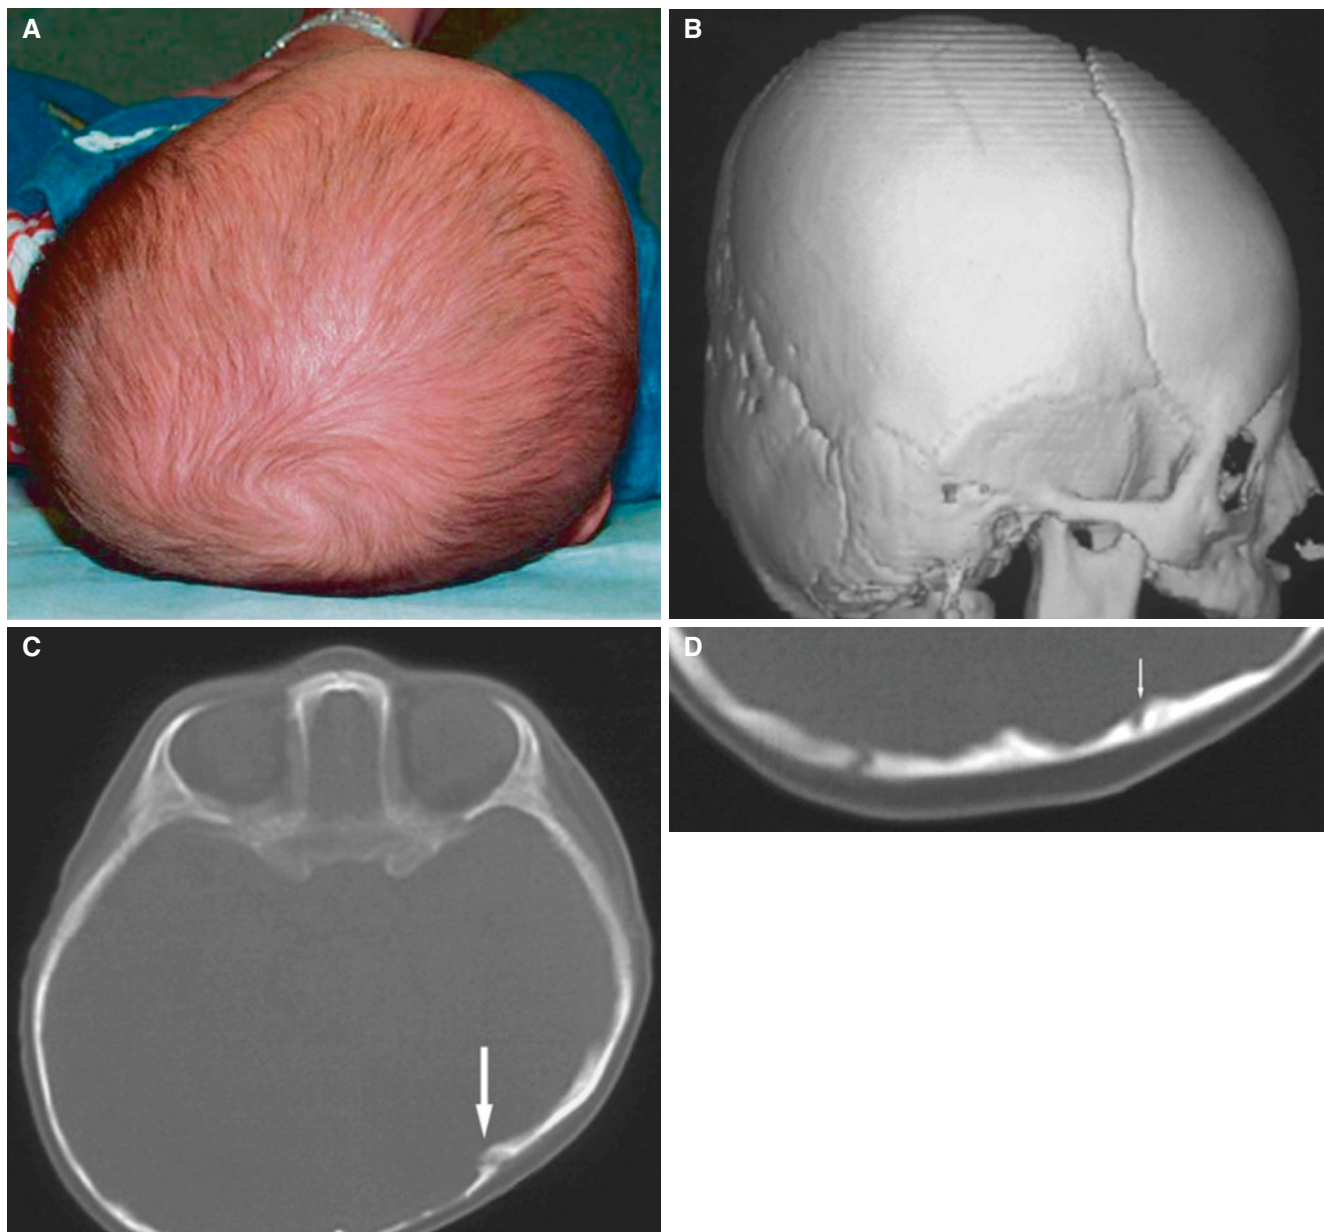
Occipital plagiocephaly unrelated to craniosynostosis; patent lambdoid suture. (A) Baby sleeping supine on one side. (B) 3D CT image shows flat head. (C) Axial CT image shows patent suture (*arrow*)
